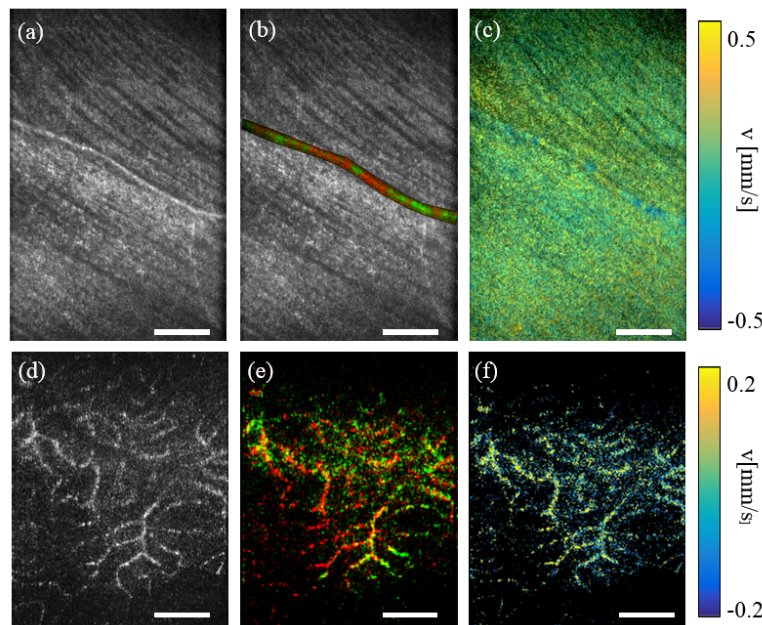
Shows an en-face Doppler calculation of the vascular flow. (a) is the OCT image with a red green map marking positive or negative flow direction in (b). (c) is the averaged Doppler shift over 20 frames. (d) is the OCT image of the microvasculature, (e) the red green map of either positive or negative flow direction and (f) the averaged Doppler shift with the velocity according to the color bar. The white scale bar indicated $200 \mu\text{m}$.
